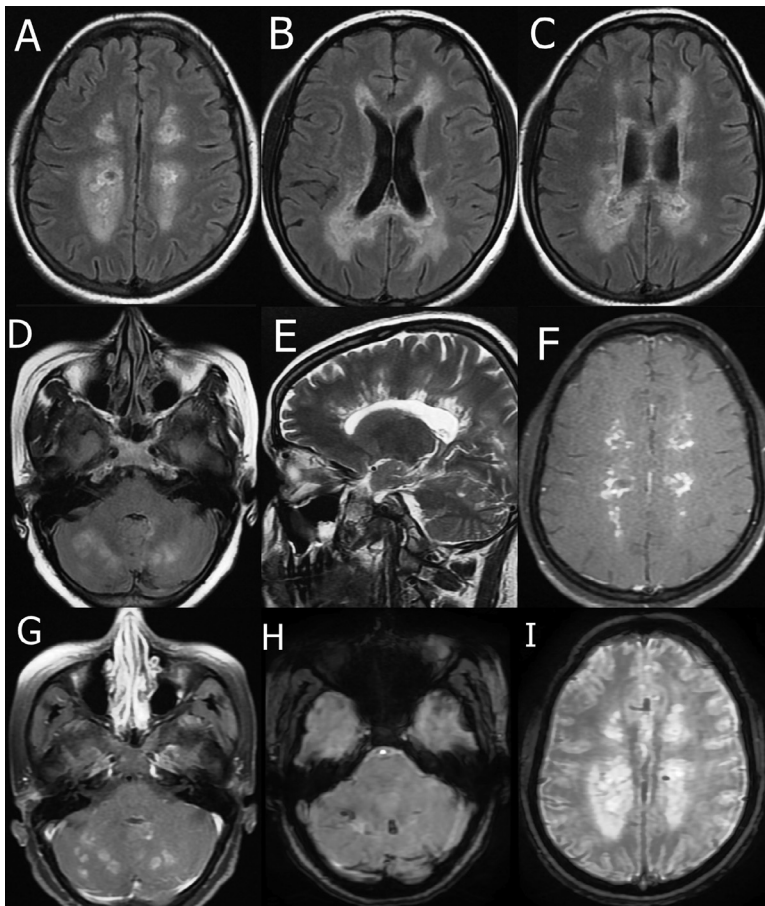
MRI brain FLAIR sequence (A–D), showing hyper-intensities involving bilateral white matter (A), splenium of corpus callosum (B), periventricular white matter (C) and cerebellum (D). T2 sagittal image (E) showing hyper-intensities involving the periventricular white matter. Post contrast T1 images (F and G) showing contrast enhancement of lesions. GRE images (H and I) showing blooming in cerebellar lesions and periventricular lesions on left side.
